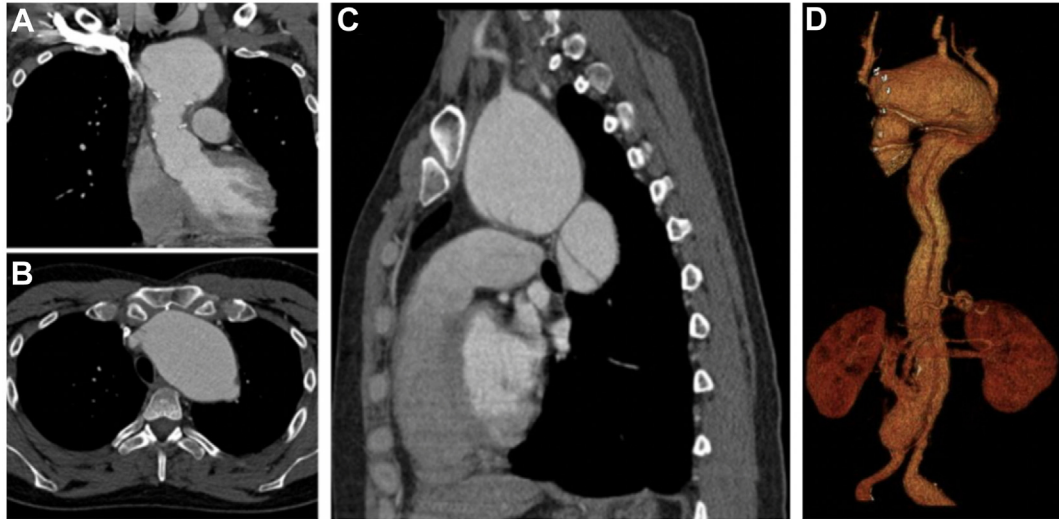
Preoperative computed tomography angiography (CTA) demonstrated degeneration of the aortic arch to 7 cm. (A) Coronal view, (B) axial view, (C) sagittal view, and (D) three-dimensional postprocessing images of a CTA examination demonstrating the degeneration of the aortic arch to 7 cm, a 4 cm infrarenal aortic aneurysm, a left common iliac aneurysm that reached 2.7 cm, and a residual aortic dissection extending into the infrarenal aorta.
